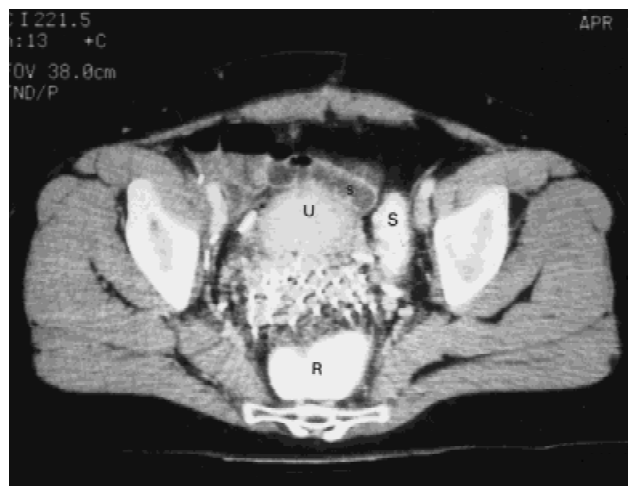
Axial CT distinguishing sigmoid (S) and rectum (R) filled with contrast, adjacent to anteverted uterus (U) and cervical needles.
